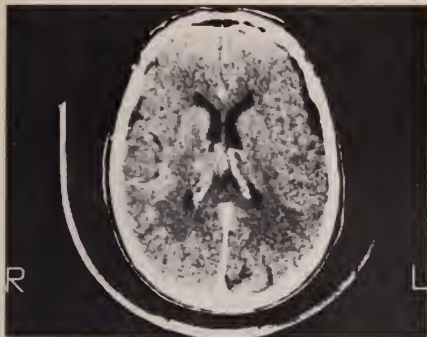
Contrast-enhanced CT scan demonstrating marked reduction of enhancing lesion in right subthalamic nucleus.
